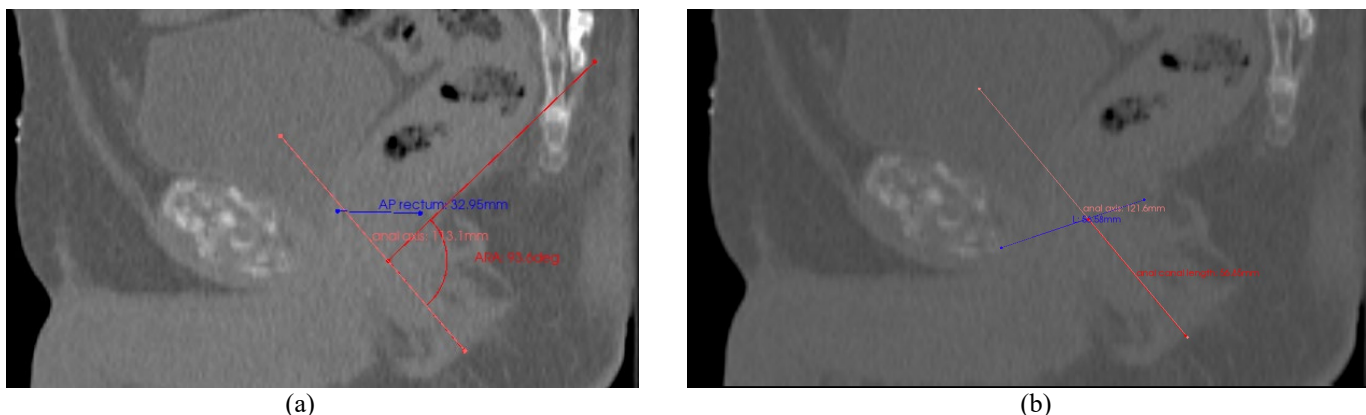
A patient's CT planning scan with annotations analysing the rectum shape and size to assess features between patients who could insert ProSpare and those who could not. (a) The anorectal angle (red) and anterior-posterior rectal diameter (blue) at the anorectal angle are measured. (b) Anal canal length (red) is measured. Pink = longitudinal axis of the anal canal.; Purple = upper boundary of the anal canal.
